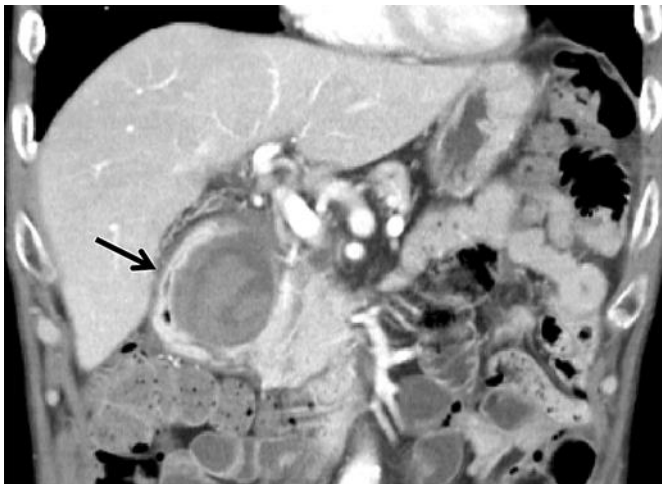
Contrast-enhanced computed tomography image showing a 4.1-cm ovoid lesion without contrast enhancement near the pancreatic head with mild dilatation of the pancreatic duct.
